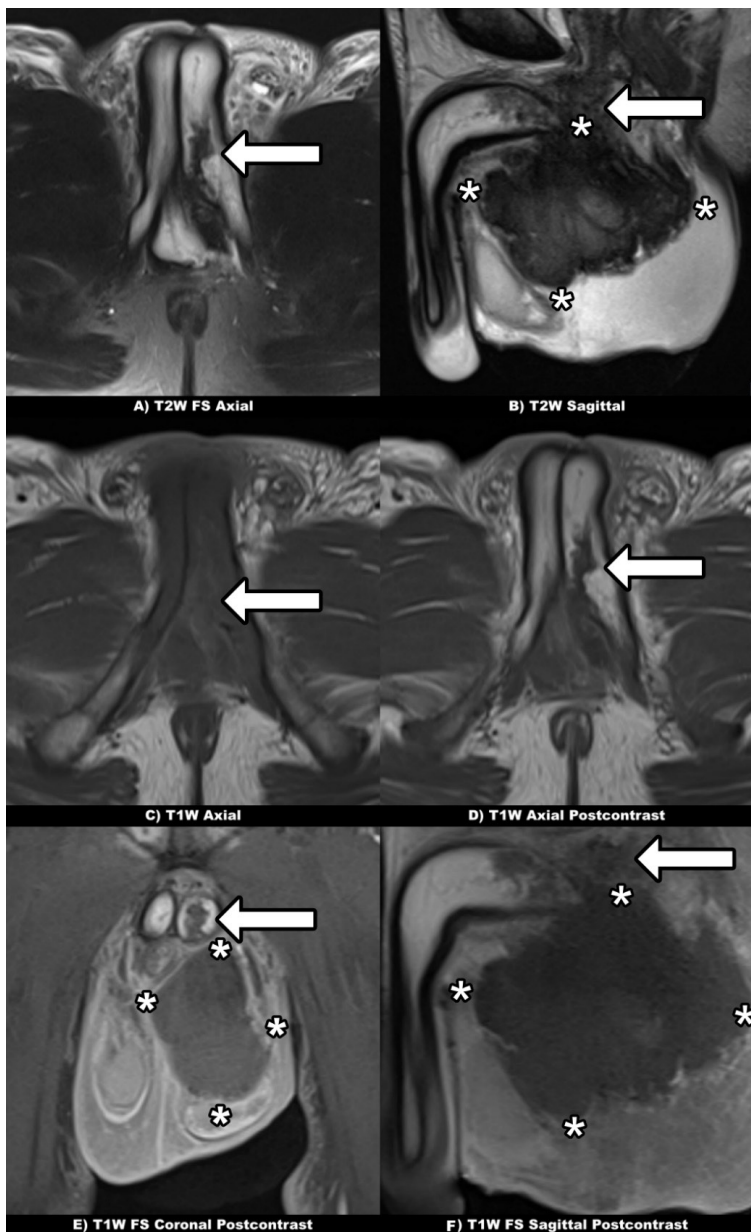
A 41-year-old male patient had pain and swelling, especially in the proximal part of the penis, due to the sudden torsion of his erect penis. After 6 days, US (not shown) and MRI were performed because the swelling increased
